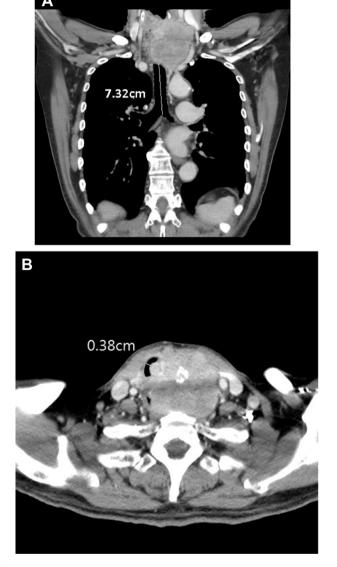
Computed tomography (CT) scan of the neck and chest. (A) Coronal section shows the tumor lying 7.32 cm above the carina and causing significant airway obstruction; (B) horizontal section shows the narrowest point of the trachea measuring 0.38 cm. Rightward deviation of the trachea is observed.
